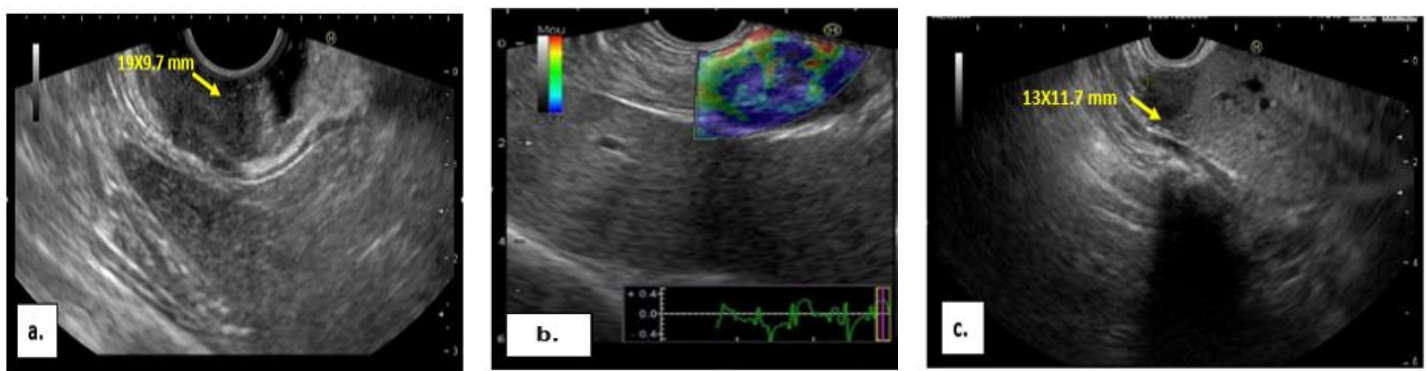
Endoscopic ultrasound features of the g-NET. a. Hypoechoic lesion of the deep part of the gastric mucosa, infiltrating the submucosa and even the muscularis, vascularized by a central pedicle. b. Perigastric lymphadenopathy, presplenic. c. Hypoechoic metastatic lesion in segment II of the liver.
